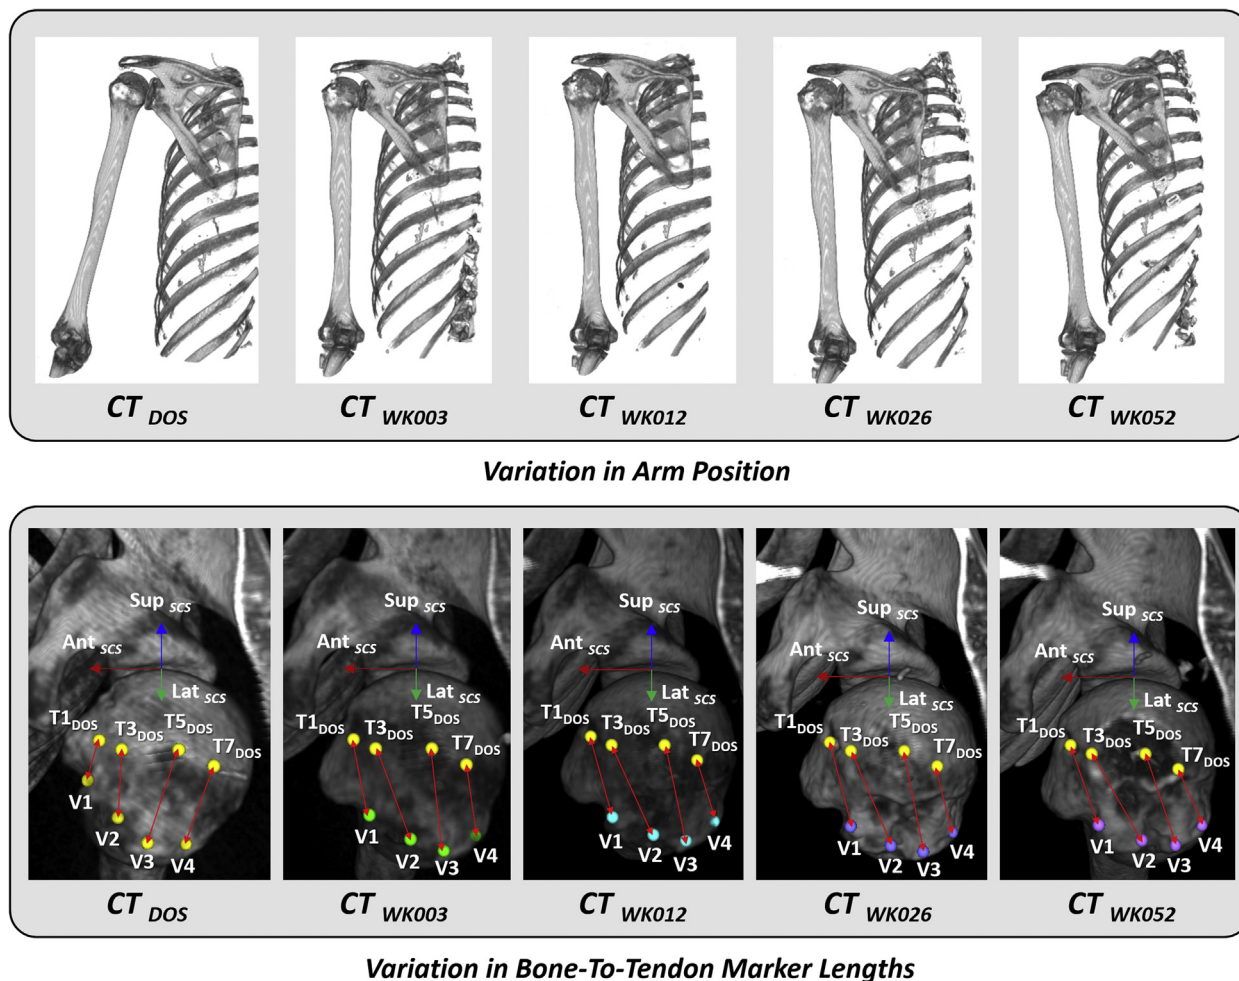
(Top) Representative longitudinal computed tomographic (CT) images of a given patient throughout the year after rotator cuff repair demonstrate variations in glenohumeral position during scanning. (Bottom) The SEMs of bone-to-tendon marker lengths due to the variation in glenohumeral position were estimated by the within-patient SDs of repeated measurements of bone-to-tendon marker lengths between the coordinates of the virtual humeral markers (V1, V2, V3, V4) on each of the 5 longitudinal CT scans and the coordinates of the tendon markers set at their day of surgery (DOS) locations (T1_{DOS}, T3_{DOS}, T5_{DOS}, T7_{DOS}). The colors of the virtual humeral markers represent the time of the longitudinal CT images (yellow: DOS; green: WK003; turquoise: WK012; purple: WK026; and pink: WK052). WK, week; Ant, anterior; Lat, lateral; Sup, superior; SCS, scapular coordinate system.
